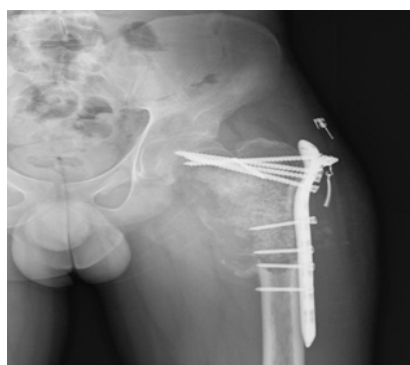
Postoperative radiograph following the second curettage-grafting
